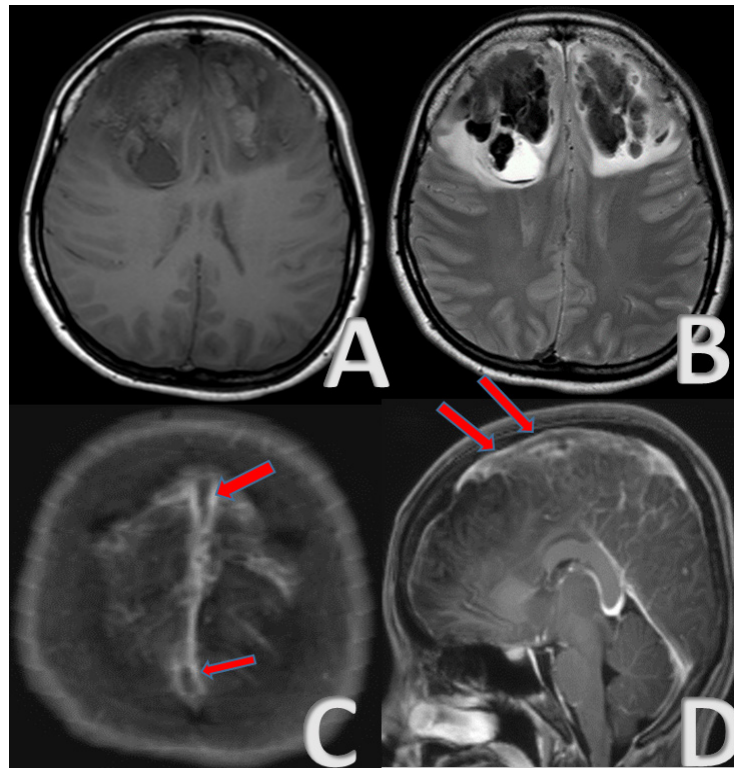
MRI brain axial T1(A) and T2(B) demonstrate bifrontal intraparenchymal haemorrhage of different ages. MR venogram axial(C) and sagittal (D), shows a similar filling defect seen in CT venogram within superior sagittal sinus (arrow).
